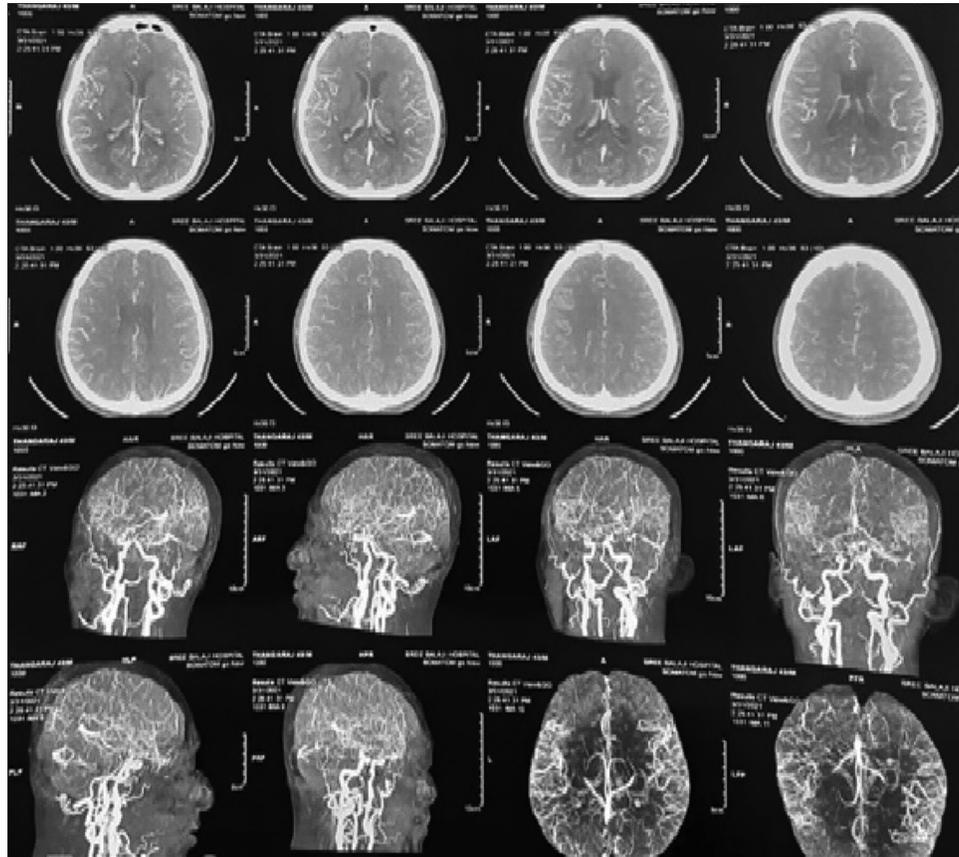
CT brain angiogram showing subarachnoid haemorrhage, few berry aneurysms in right MCA and proximal ACA and also “puff of smoke” like appearance (MoyaMoya disease)
